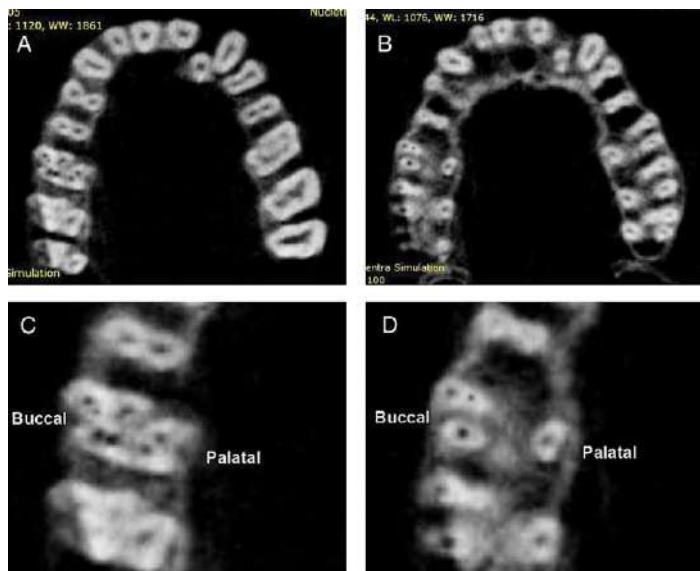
1.(A and B) CBCT images of #3 showing axial sections at the (A) cervical and (B) apical level. (C and D) Enlarged axial section CBCT images at the (C) cervical and (D) apical level showing three roots and seven canals.
